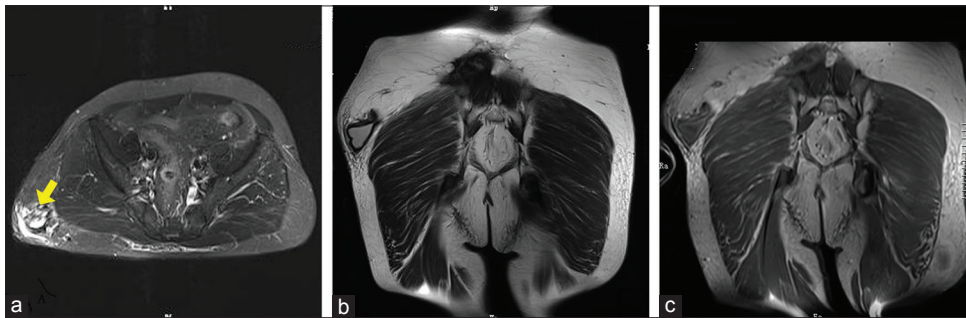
Imaging findings of a 57-year-old man (patient 16). (a) T2-weighted axial (arrow) and (b) T2-weighted coronal MRI scans showed the lesion was located in the subcutaneous soft tissue of the hip. (c) The cystic wall of the lesion was slightly enhanced, following administration of the contrast agent. MRI: Magnetic resonance imaging.
